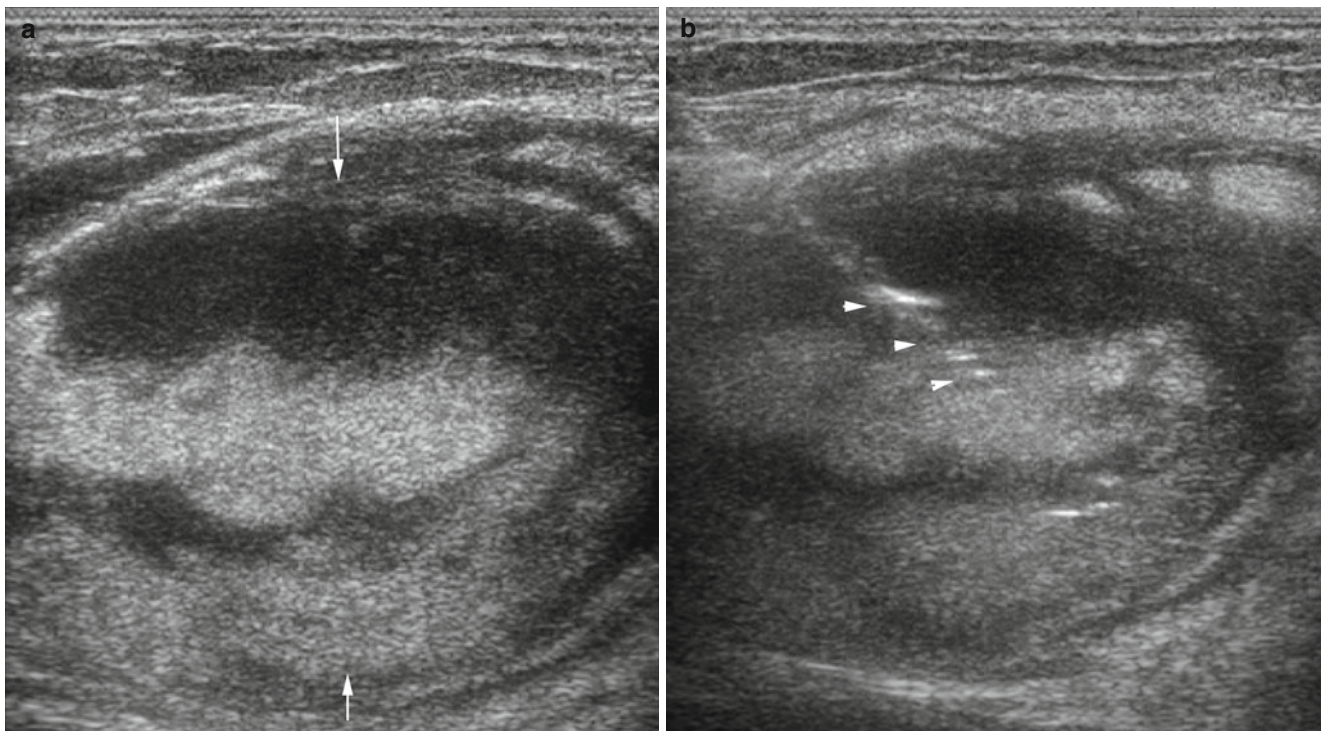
A 77-year-old male, complaining of painless nodule in right inguinal region. (a) Grey-scale ultrasound image shows heterogeneous echogenic nodule (*arrows*), mixed with hypoechoic and hyperechogenicity. (b) Ultrasound-guided core biopsy (*arrowheads*) through the hypoechoic
